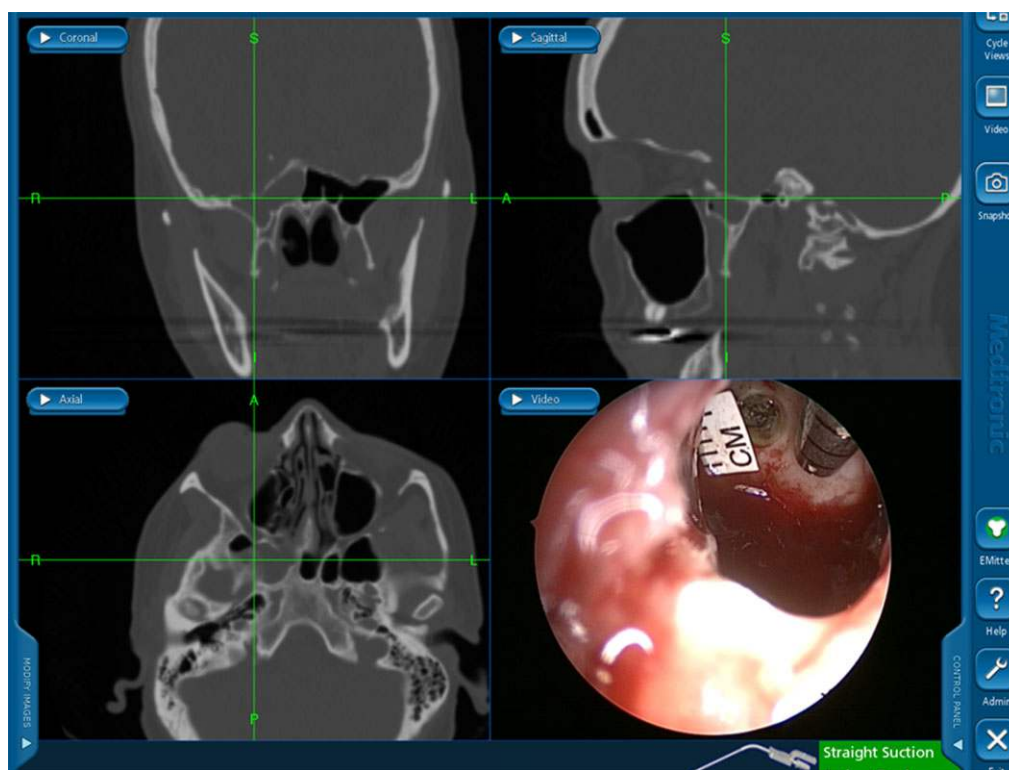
Triplanar CT imaging with endoscopic view through a transpterygoid approach following resection of the encephalocele in a morbidly obese female. Note the location lateral to V2. CT = computed tomography; V2 = maxillary nerve (cranial nerve V2).
